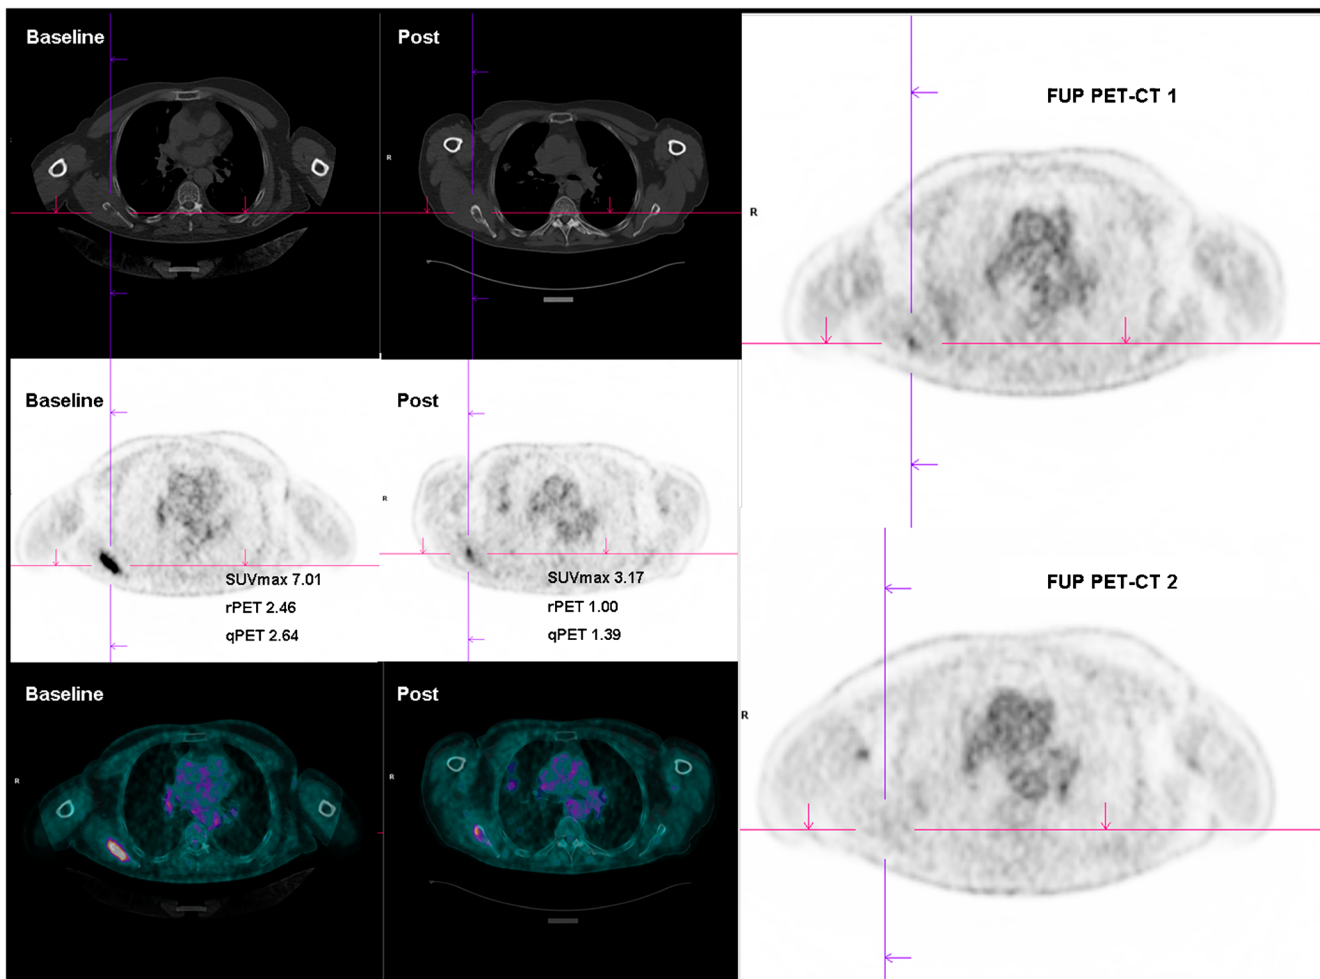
A 54-year-old male. Baseline PET-CT shows a single area of focal ^{18}F -FDG uptake on a lytic lesion involving right scapula (SUVmax 7.01; rPET 2.46; qPET 2.64); post-treatment PET-CT shows a decrease in ^{18}F -FDG uptake by the same lesion (SUVmax 3.17; rPET 1.00; qPET 1.39), morphologically stable. Δ values obtained (ΔSUVmax 3.84; ΔrPET 1.46;
